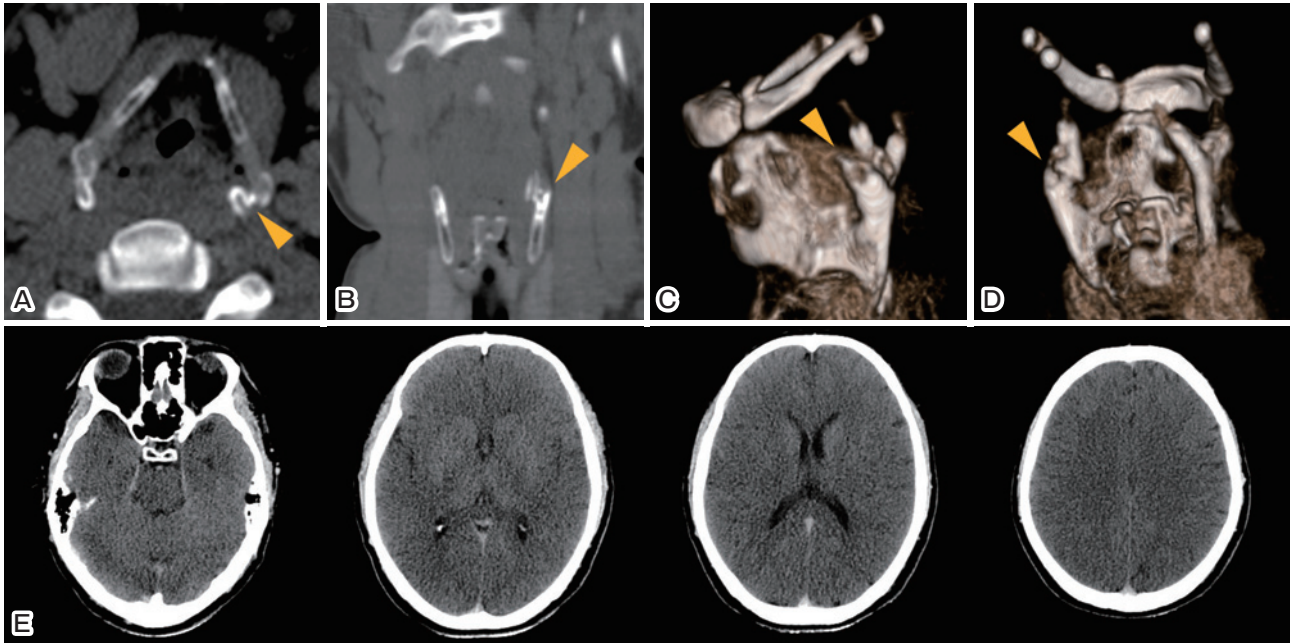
A fracture of the left superior horn of thyroid cartilage diagnosed on CT (A and B) and 3D-volume-rendering images; lateral (C) and posterior (D) views. CT scans of the brain showed loss of the gray-white matter interface and obscuration of the lentiform nucleus and sulcal effacement (E).
